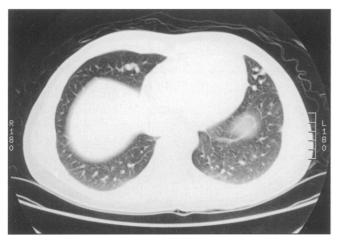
CT scan of chest showing the typical serpiginous characteristic of AVMs within the lingula and right middle lobe.
